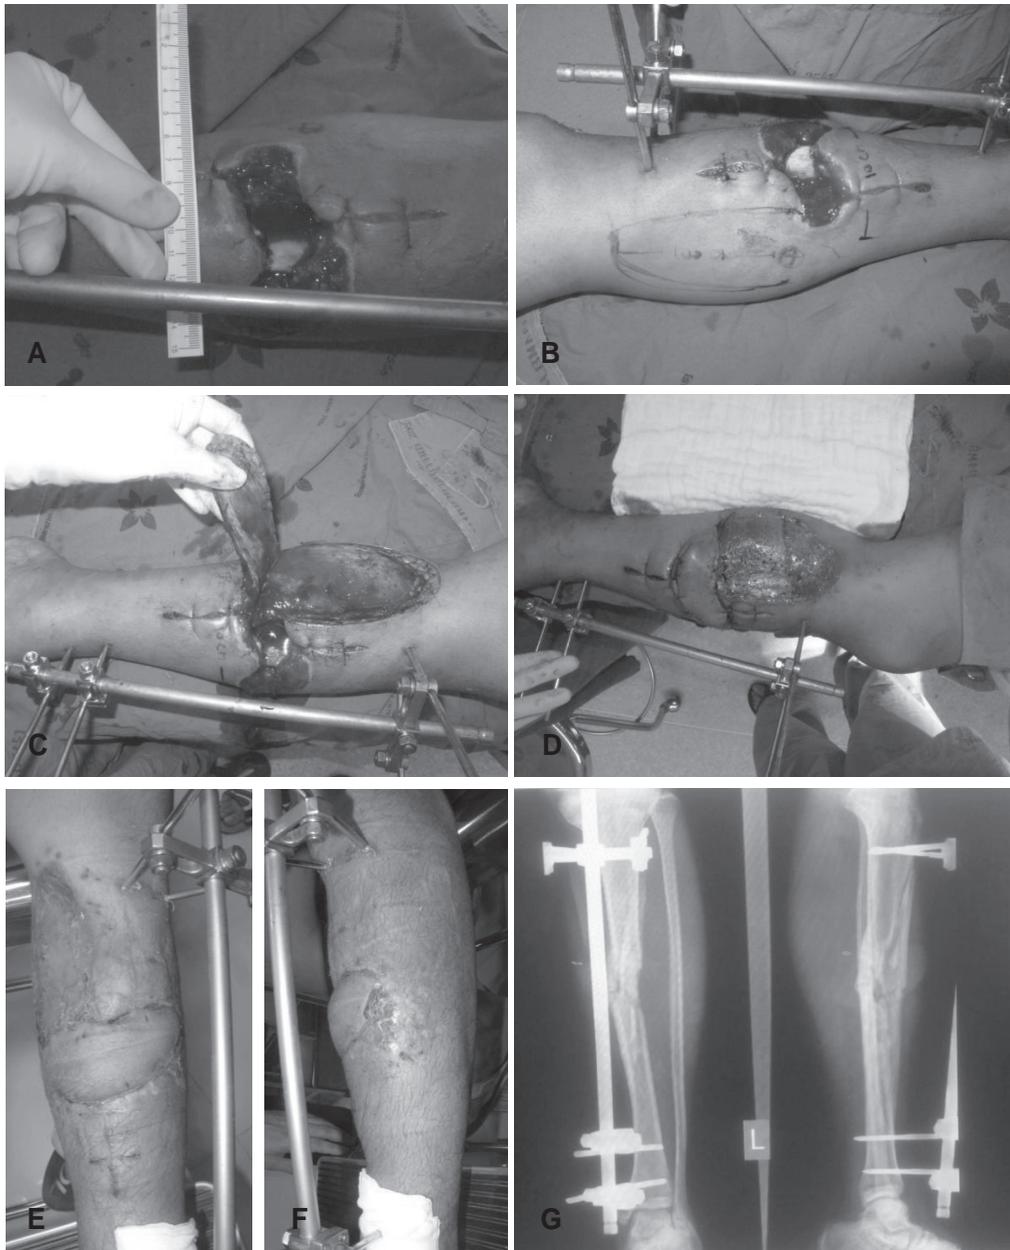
(A) Preoperative view. (B) Marking perforator by hand held Doppler ultrasound flap design. (C) Elevation of perforator transposition (D) Immediate after operation, the defect was covered by perforator transposition fasciocutaneous flap and donor site was covered by spit-thickness skin graft. (E, F) View at 2 months follow-up complete survival of flap and skin graft on the donor site. (G) Film left leg at 2 months after surgery
